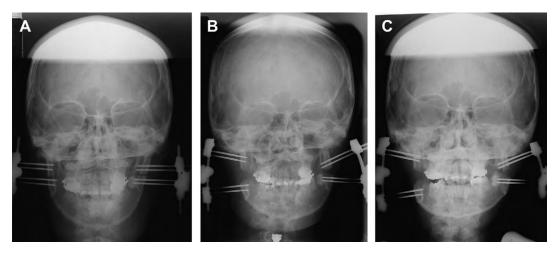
Frontal radiographs of the patient shown in Fig. 11. (A) Radiograph taken immediately after device placement shows parallel pins and right-to-left symmetry. (B) After 4 weeks of distraction, the pins are beginning to converge toward the bone, activation becomes more difficult and painful, and facial, skeletal, and occlusal asymmetry is developing. (C) After 6 weeks of distraction, all findings shown in B have worsened, and the medial surface of ramus demonstrates boney consolidation on the left side.
